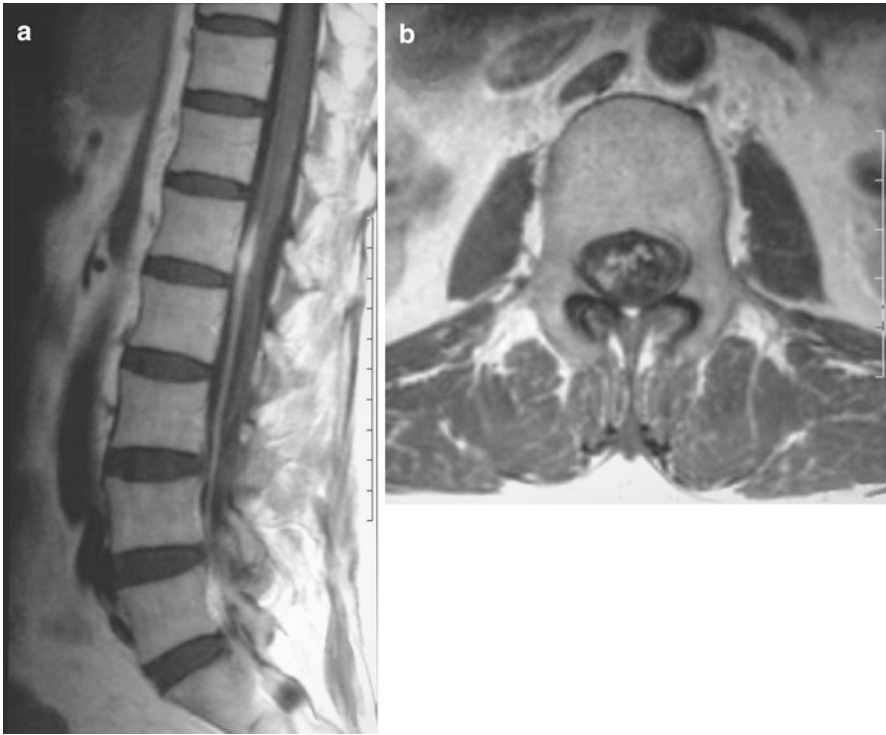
Magnetic resonance imaging showing nodular thickening of the cauda equina roots in a patient with tuberculous meningitis and lumbosacral root involvement. Sagittal (a) and axial (b) T1-weighted sequences after gadolinium administration
